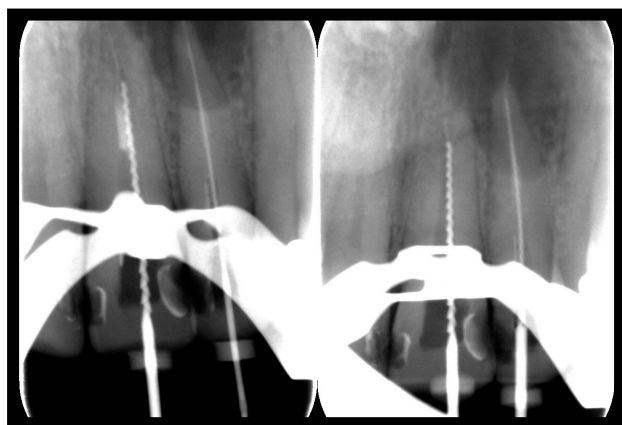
Treatment radiographs. Left: Incremental removal of guttapercha; Right: Working length
